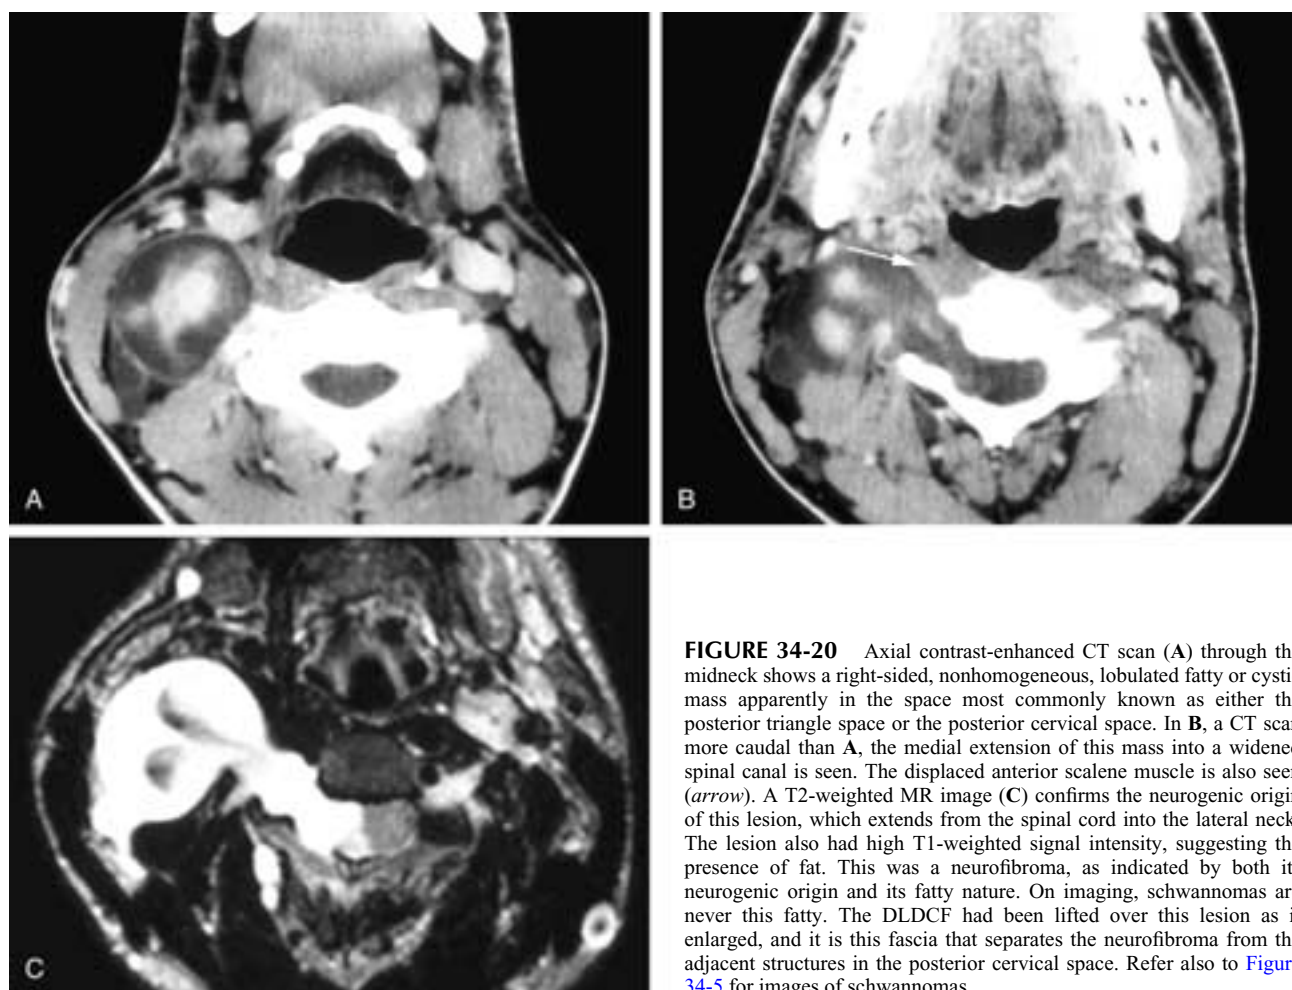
Axial contrast-enhanced CT scan (A) through the midneck shows a right-sided, nonhomogeneous, lobulated fatty or cystic mass apparently in the space most commonly known as either the posterior triangle space or the posterior cervical space. In B, a CT scan more caudal than A, the medial extension of this mass into a widened spinal canal is seen. The displaced anterior scalene muscle is also seen (arrow). A T2-weighted MR image (C) confirms the neurogenic origin of this lesion, which extends from the spinal cord into the lateral neck. The lesion also had high T1-weighted signal intensity, suggesting the presence of fat. This was a neurofibroma, as indicated by both its neurogenic origin and its fatty nature. On imaging, schwannomas are never this fatty. The DLDCF had been lifted over this lesion as it enlarged, and it is this fascia that separates the neurofibroma from the adjacent structures in the posterior cervical space. Refer also to Figure 34-5 for images of schwannomas.
